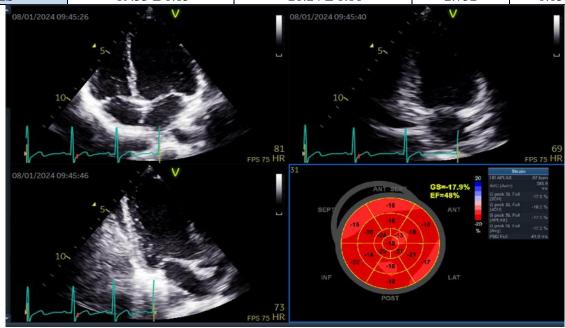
Speckle tracking Echocardiography bull's eye showing decreased GLS (-17.9).
